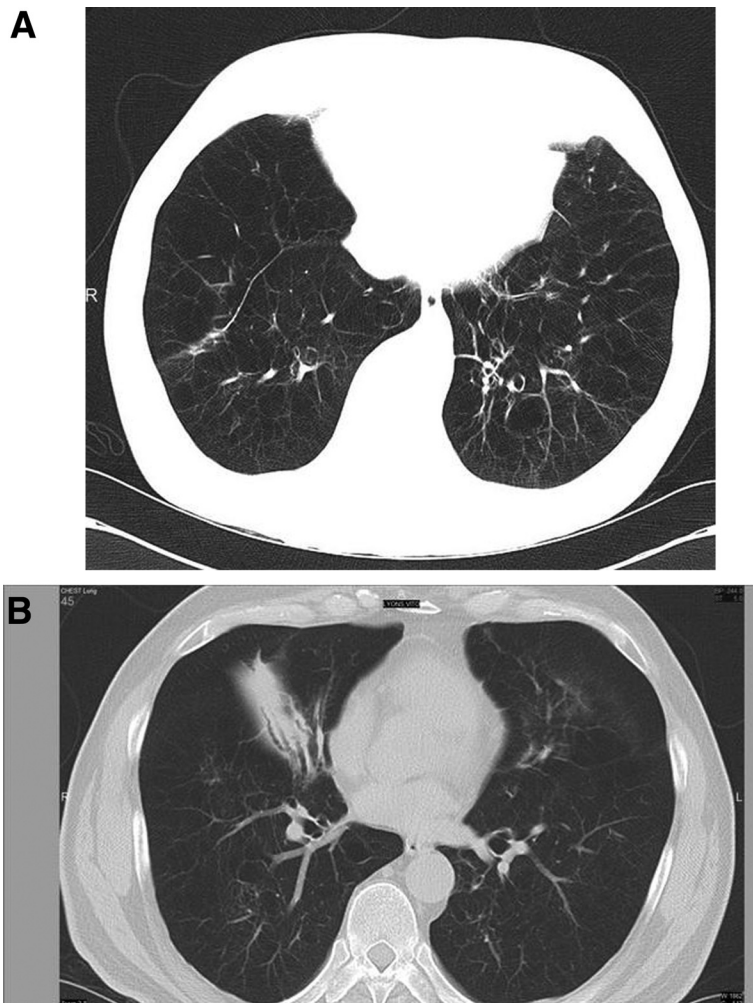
(A and B) CT scan of the chest showing pulmonary hyperinflation with pulmonary emphysema and traction bronchiectasis.
